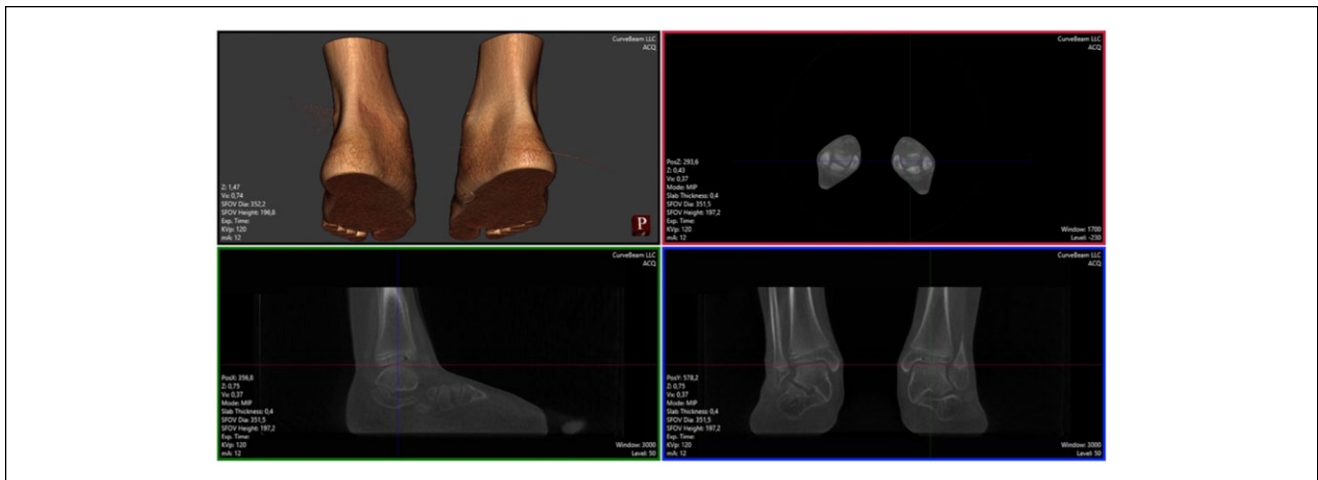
3D views obtained by the weightbearing computed tomography built-in software.
